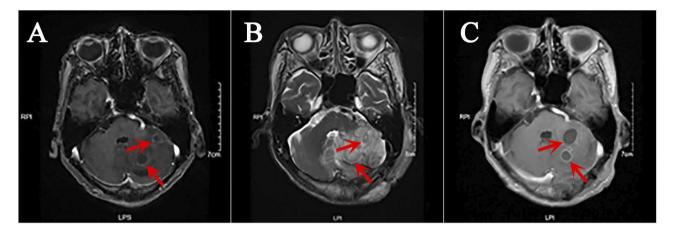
MRI images of the patient's head. (A) MRI images of the patient upon admission. (B) MRI images of the patient after surgery. (C) MRI images of the patient two weeks after surgery. The locations of Abscess lesions were indicated by the red arrow
